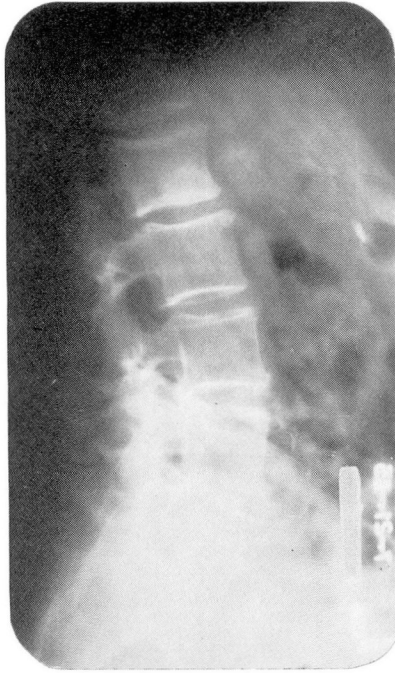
Roentgenogram, lateral view showing pancreatic calculi.
